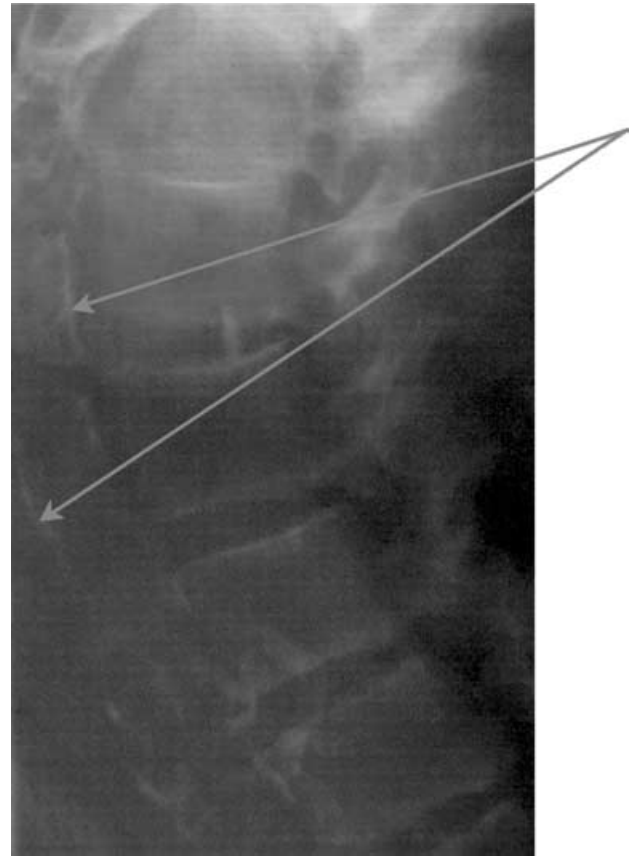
Plain x-ray film showing tram-line medial calcification.
